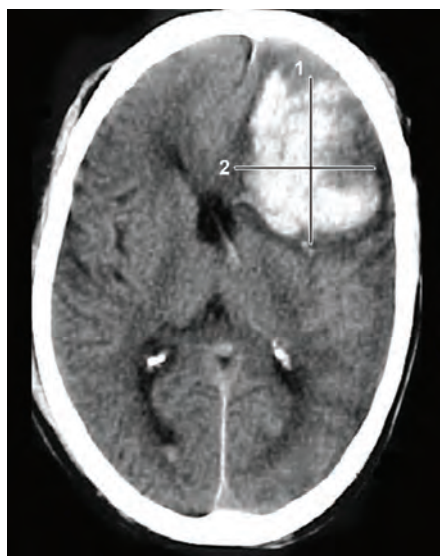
CT scan of the brain showing post-traumatic haematoma in the frontal lobe
